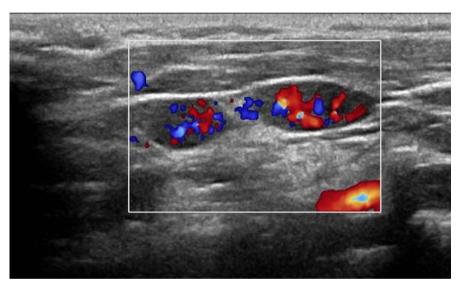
Doppler scan of cervical lymph nodes showing increased vascularity.
